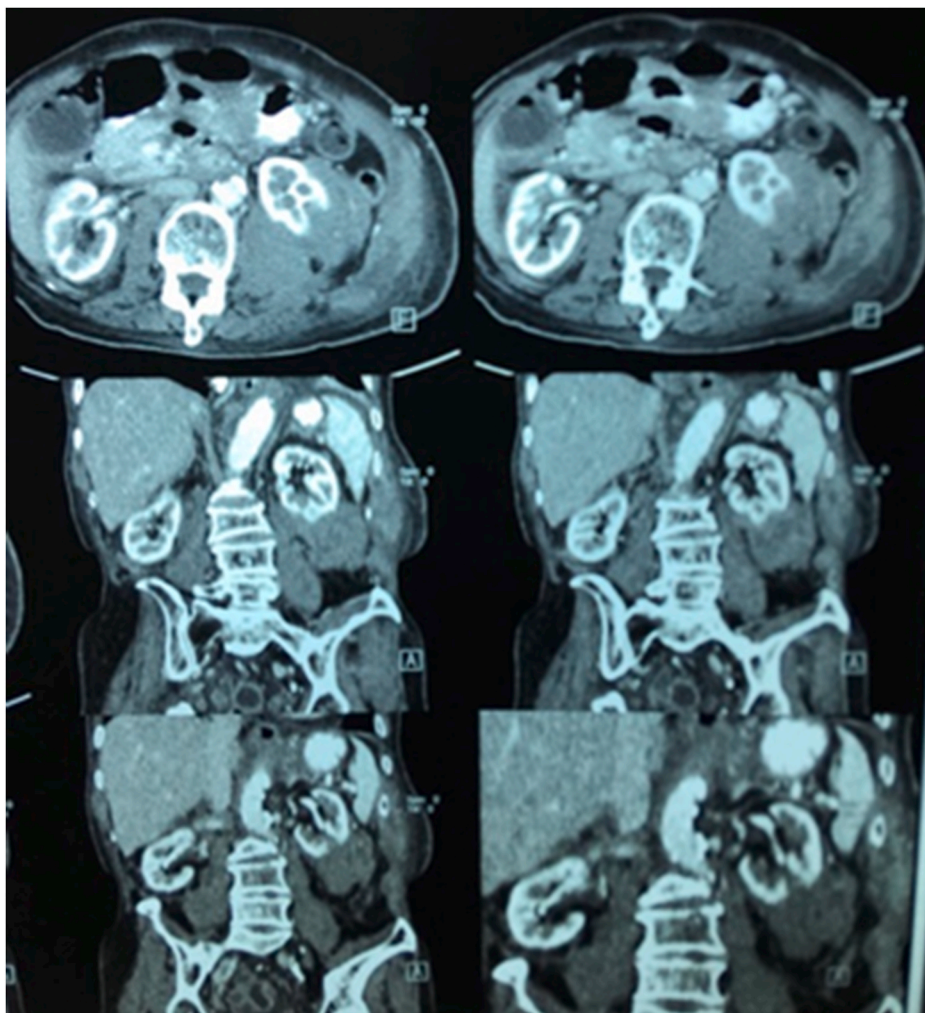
Hyperdense lesion at the left kidney in the abdominal pelvis CT-Scan with contrast.
